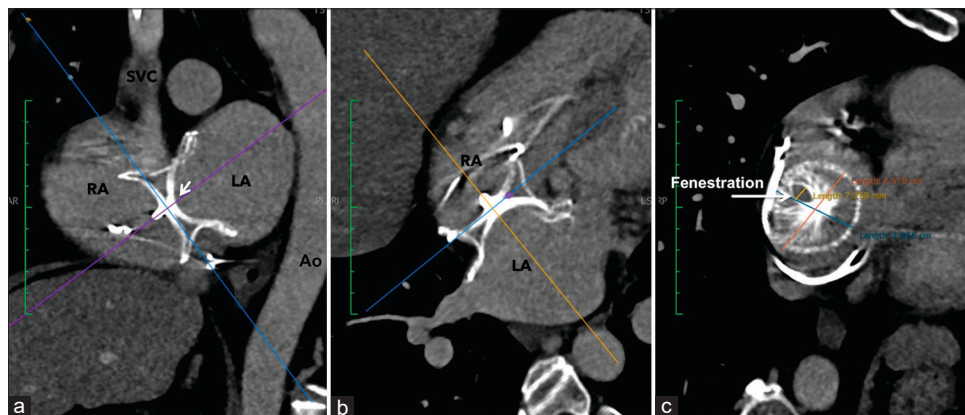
Multiplanar reformatted computed tomographic images in modified sagittal (a), axial (b), and coronal (c) views demonstrated good remodeling of the RA. The device waist measured 46 mm in the coronal plane and fenestration measured 7 mm. RA: Right atrium
